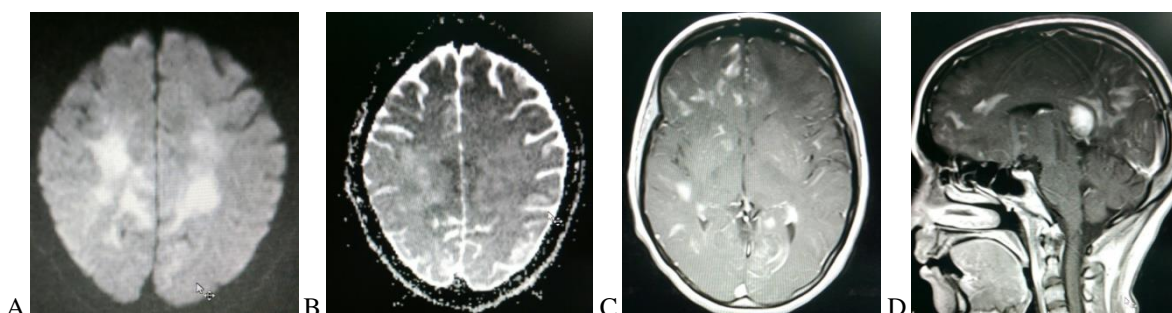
Diffusion-perfusion MRI show that bilateral restrictive pattern (A,B) in the axial and sagittal T1 sequences with contrast in most lesions have a homogeneous enhancement (C,D).
